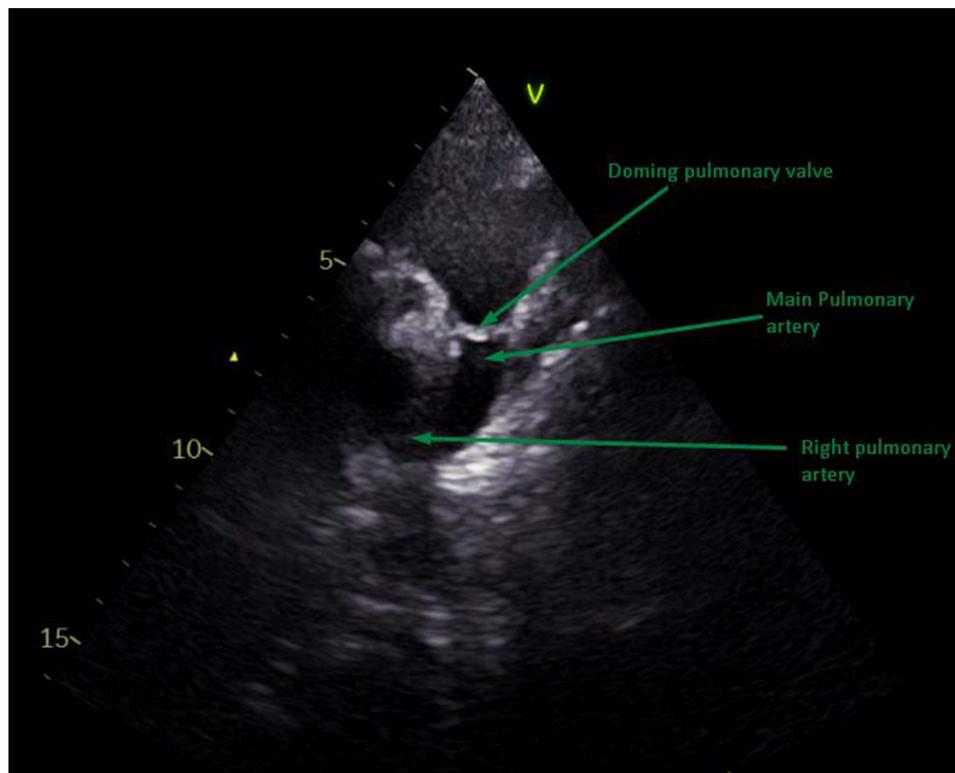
Echocardiography showing continuation of main pulmonary artery as right pulmonary artery and absence of left pulmonary artery.
